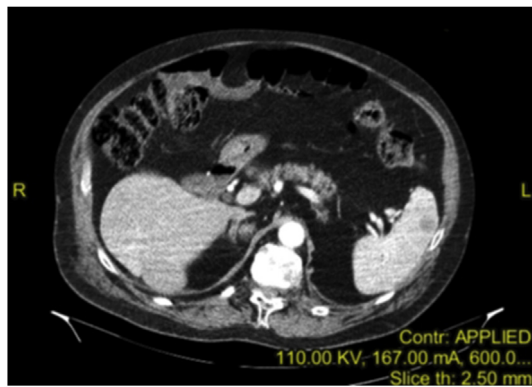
Right adrenal on CT-scan.
